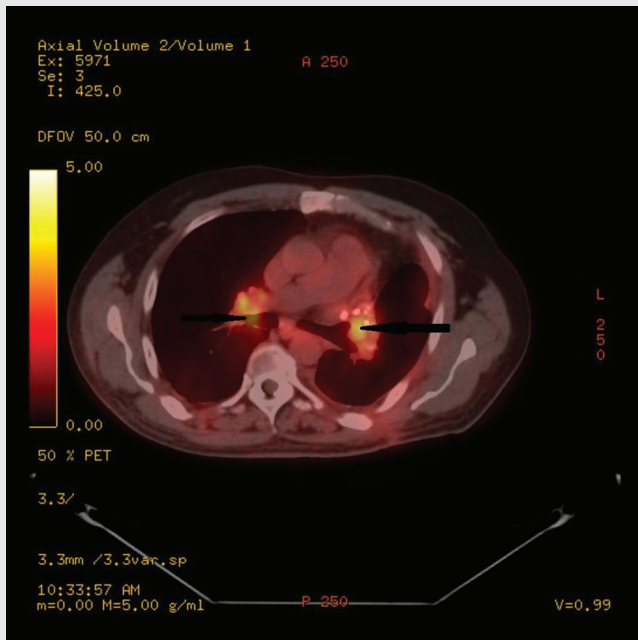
Post-Operative bilateral lymphadenopathy: PET/CT image showing bilateral mediastinal lymphadenopathy (indicated by arrows) persisting after surgical removal of the tumor. This was initially worrisome for metastasis; however, lymph nodes biopsied during surgery had not shown any malignancy. The absence of malignancy in the draining lymph nodes made it unlikely that these nodes were hypermetabolic due to malignancy. It is much more likely that the increased uptake was due to the coal worker's pneumoconiosis and the sarcoid-like reaction.
